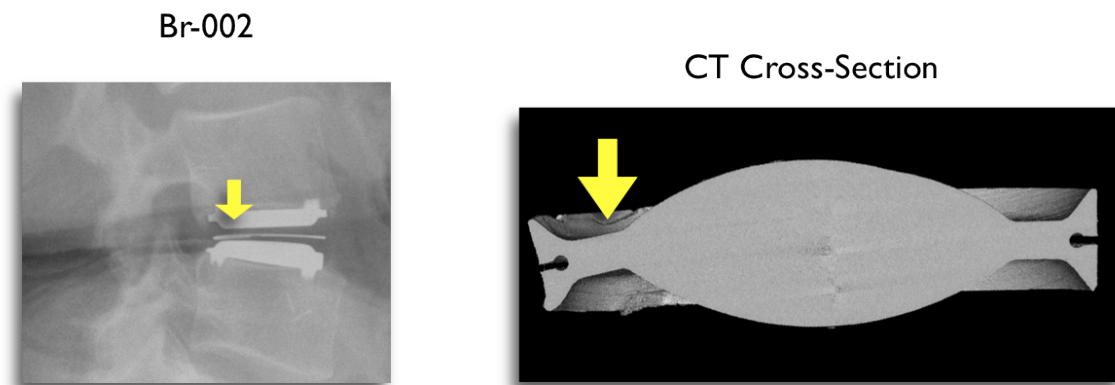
Pre-revision sagittal radiograph (left) and micro CT cross-section (right) from a retrieved implant displaying downward bending of the posterior rim.
